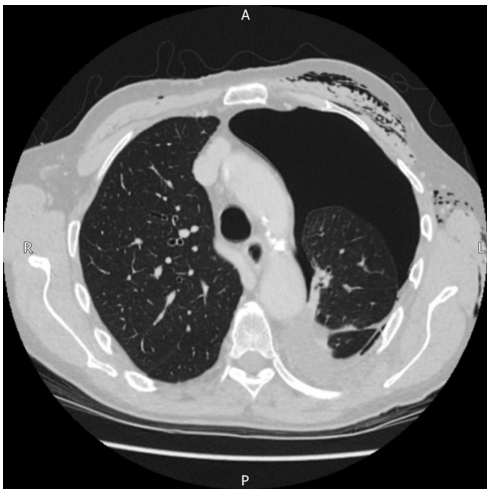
CT in the same patient shown in Fig. 8.7—blunt chest trauma, comprising rib fractures, subcutaneous emphysema, a left pneumothorax, and a small haemothorax.
